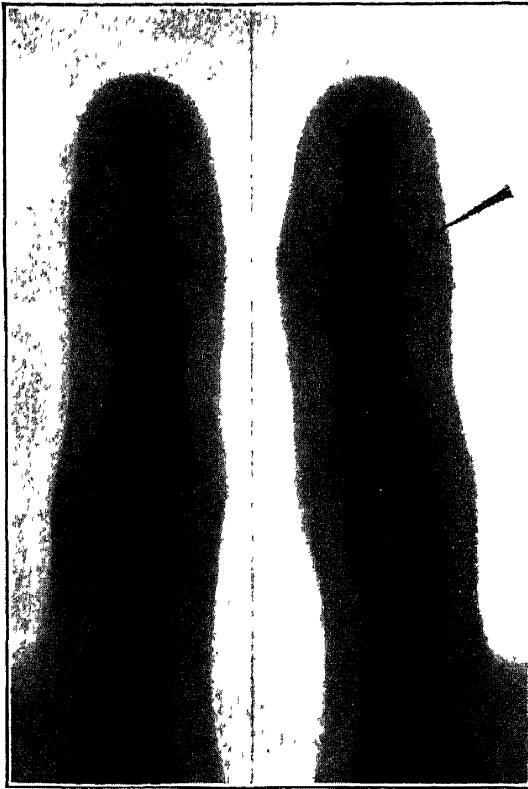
RADIOGRAPH OF TRAUMATIC DROP-FINGER, ANTERO-POSTERIOR VIEW. A portion of the terminal phalanx has been torn off with the posterior ligament.
